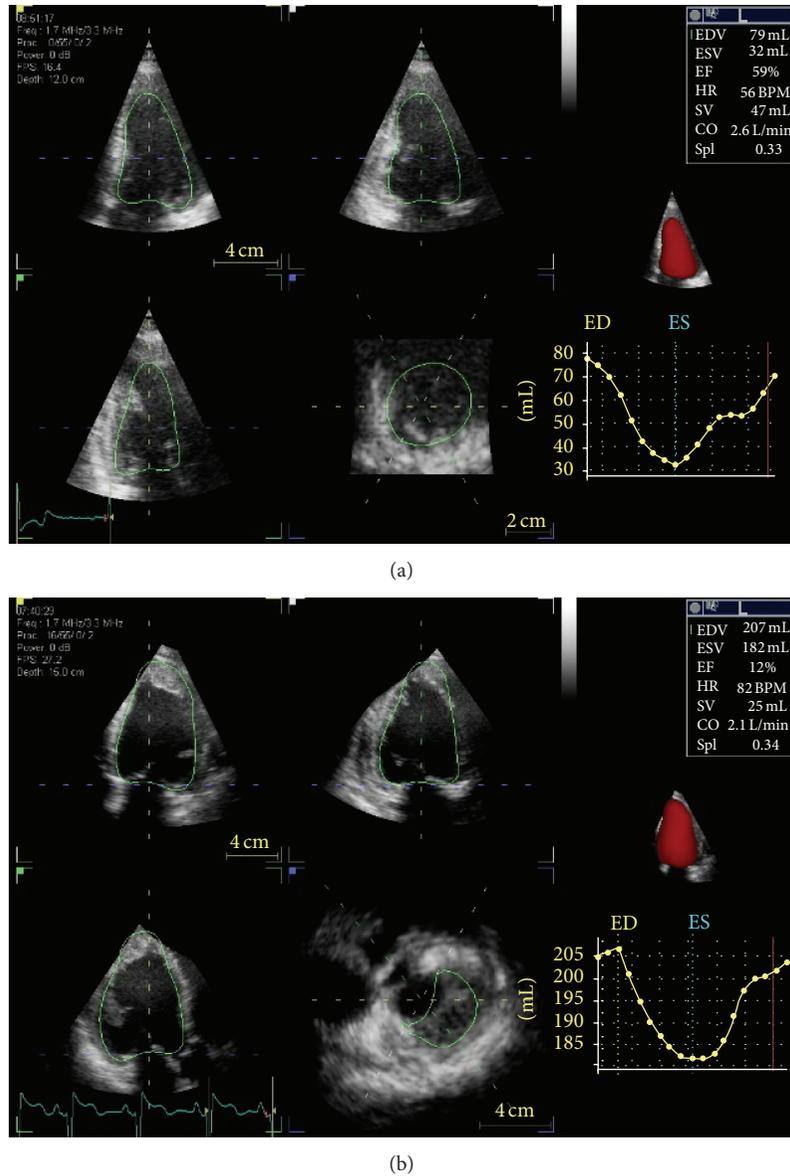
Three-dimensional echocardiography: evaluation of left ventricular ejection fraction in a normal patient (a) and in one with impaired function (b).
